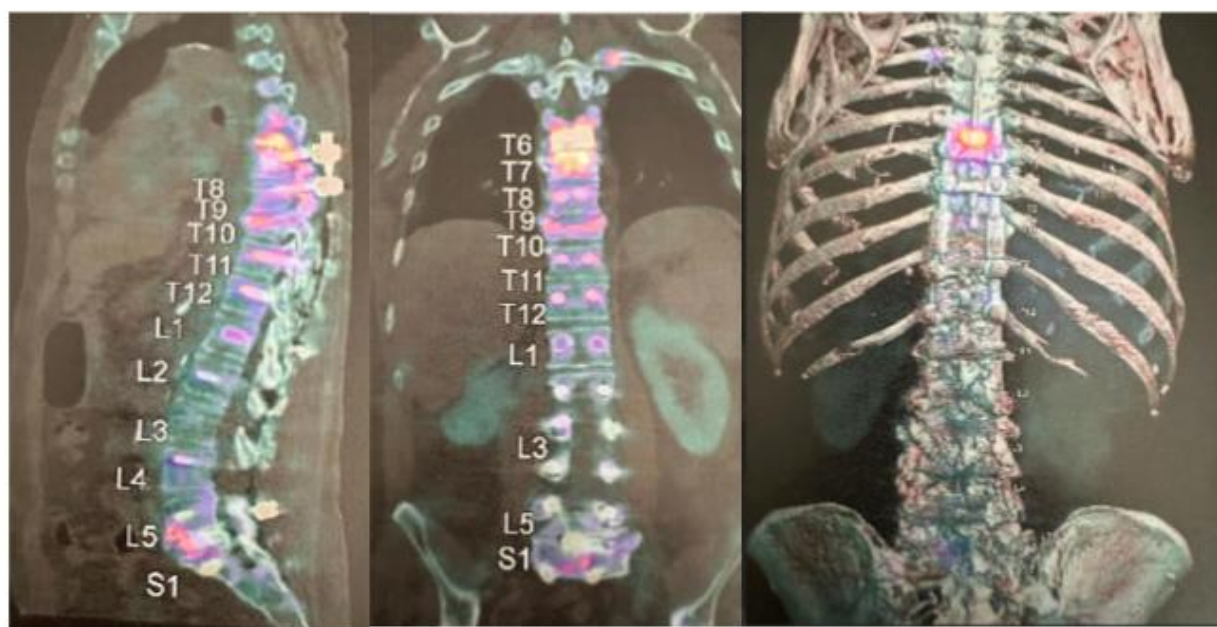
Sagittal, coronal and 3D fused SPECT-TC demonstrate increased radiotracer uptake at the T6-T7 vertebral bodies, which suggest symptomatic pseudarthrosis. Increased radiotracer uptake is evident at T6, T7, T8, T9, T10 and T11 level, concerning for pedicle screws loosening.
